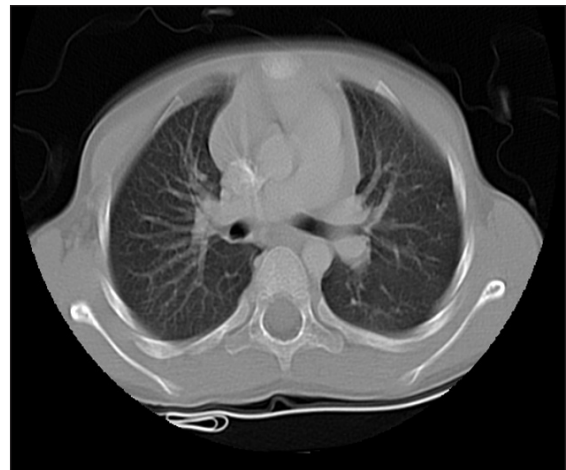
CT scan of the chest three months after treatment showed complete resolution of the mass.
